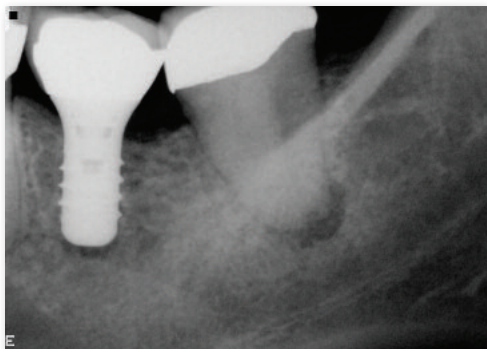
A preoperative radiograph shows presence of a periradicular pathosis in the mandibular left second molar. A dentist initially recommended extraction and replacement of this tooth with an implant. The patient requested a second opinion from an endodontist who found the tooth to be treatable.
